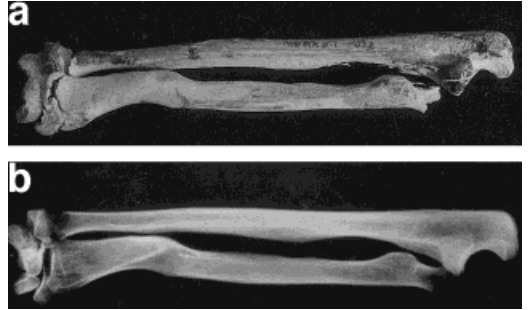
a: Healed fracture of the diaphysis of the radius (case M1032, adult female). b: Radiograph of same case.
